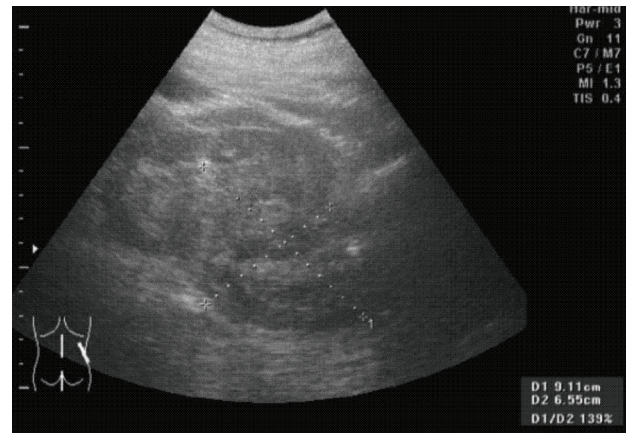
Ultrasonography. A heterogenous echogenic mass was found in the right kidney, 9.1x6.5 cm in size
